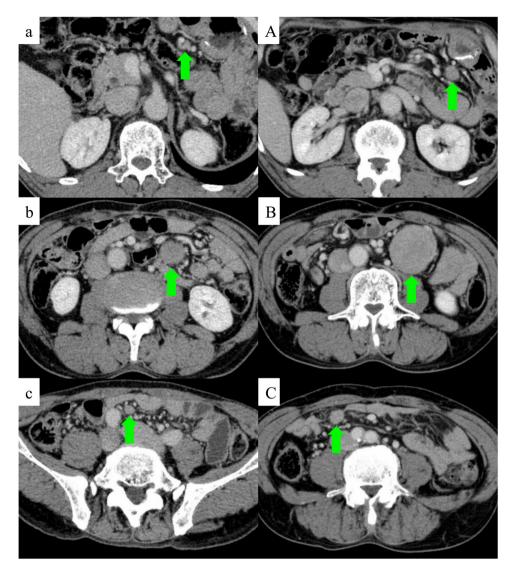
CT showing 3 enhanced, round-shaped masses mimicking gastric cancer lymph nodes or peritoneal dissemination recurrence that increased in size but not in number. Small characters indicate the CT a year after gastrectomy, and large characters indicate the CT two years after gastrectomy. a: 0.5 cm, b: 2.5 cm, c: 1.0 cm in diameter. A: 1.5 cm, B: 4 cm, C: 1.5 cm in diameter.
